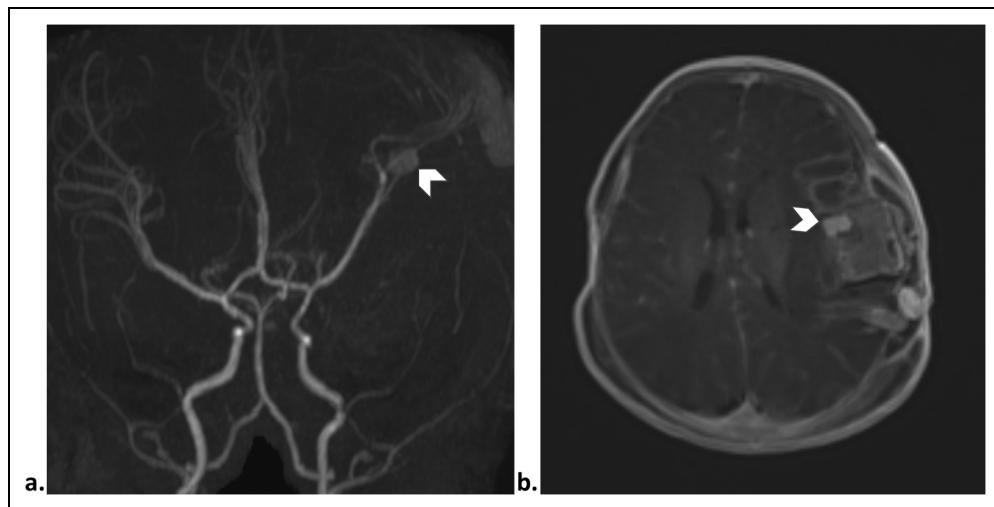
In the neonatal period, three-dimensional reconstruction of time-of-flight magnetic resonance angiography of the head demonstrates a large, ruptured aneurysm involving the inferior division of the M2 and M3 segments of the left middle cerebral artery (a) and contrast-enhanced T1 axial brain magnetic resonance imaging (b) demonstrates the aneurysm with surrounding subarachnoid hemorrhage.
